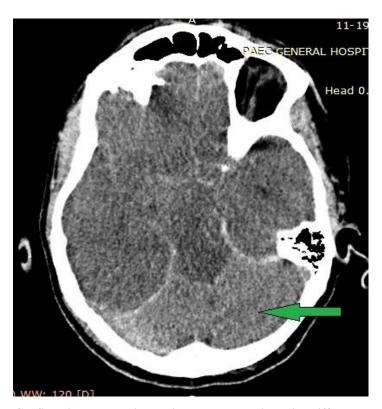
Axial CT-Scan image showing white cerebellum sign with diffuse cerebral edema.
